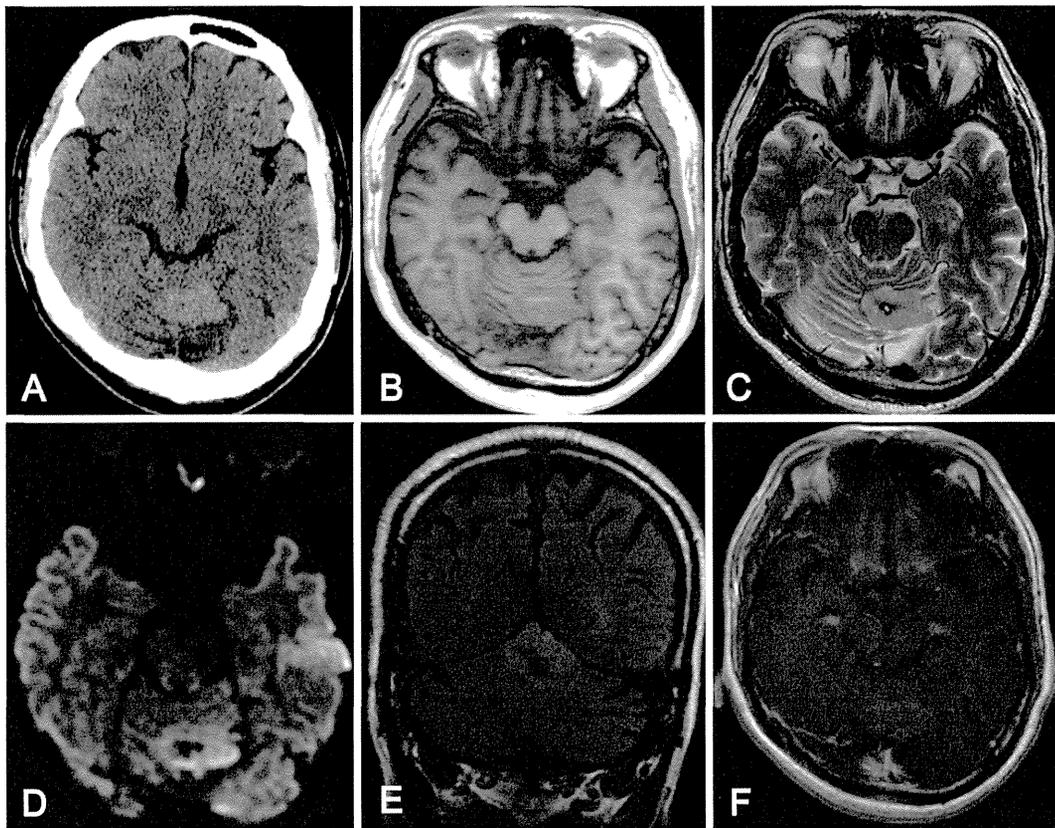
Computed tomography (CT) and magnetic resonance imaging (MRI). a Axial CT, b T1-weighted axial MRI, c T2-weighted axial MRI, d diffusion-weighted axial MRI, e coronal fluid-attenuated inversion recovery MRI, f gadolinium-enhanced T1-weighted axial
